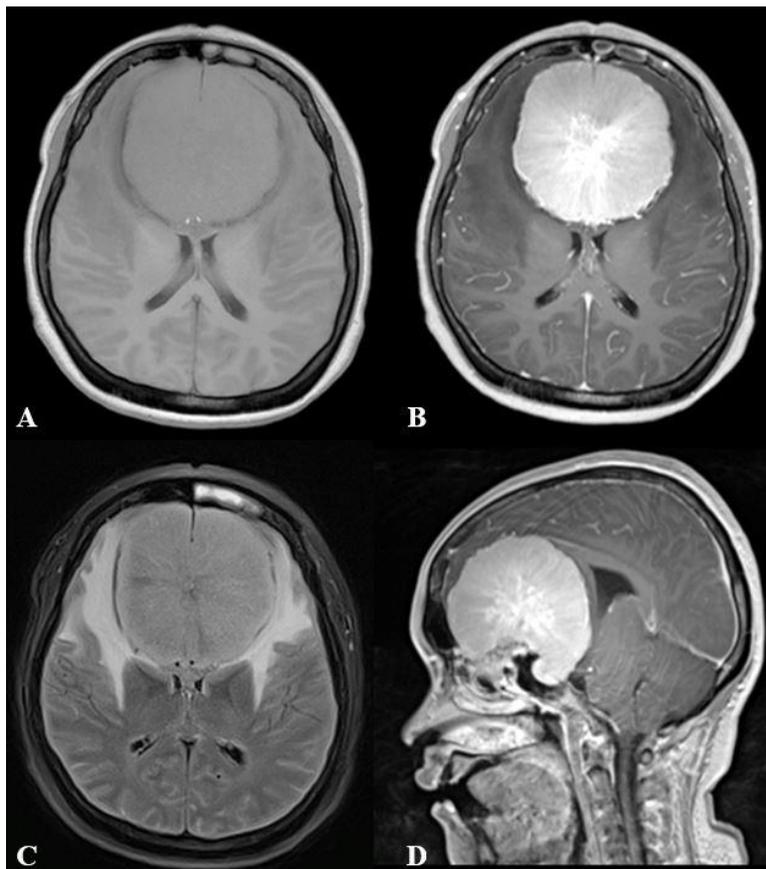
Head MRI of 36 y.o. female with meningothelial meningioma, axial T1WI (A), T1 post-contrast (B), T2-FLAIR (C), and sagittal T1 post-contrast (D). A sizable extraaxial mass with peritumoral oedema and strong homogenous contrast enhancement was noted on olfactory groove, pushing adjacent brain parenchyma and ventricular system. Also note abnormal signal intensity on left frontal sinus.
